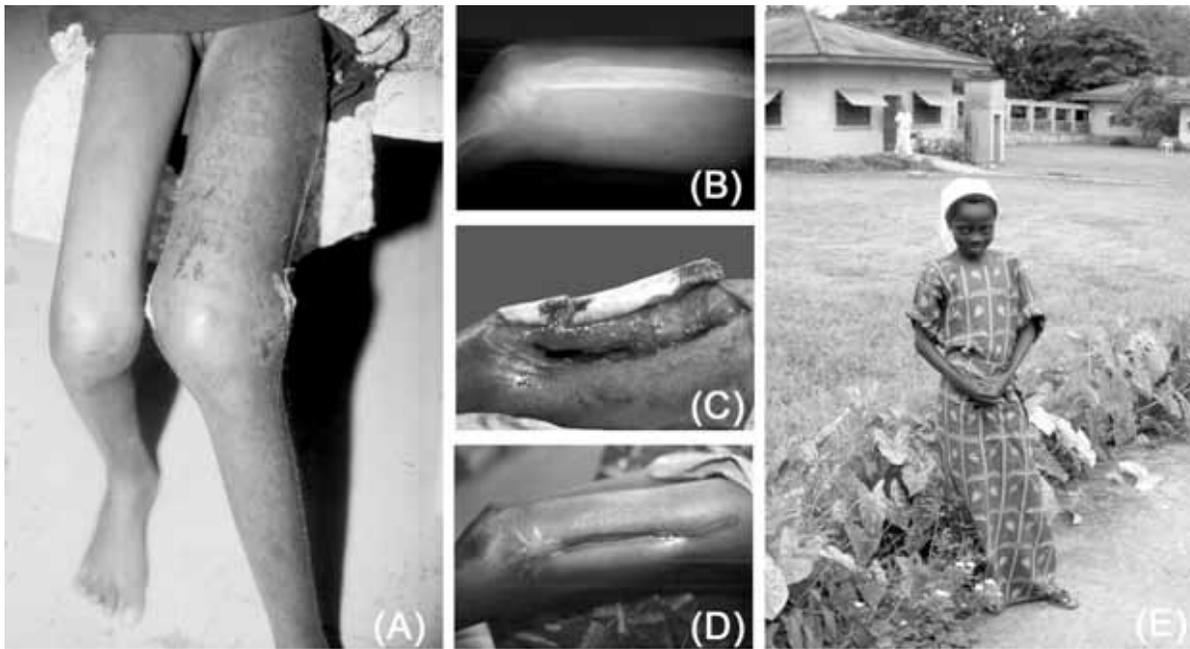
Stage 4 HO in a 12-year-old female with sickle-cell (SS) haemoglobin: (A) initial presentation with large abscess of left thigh, (B) x-ray showing giant sequestrum of femur, (C) drainage of abscess and sequestrectomy performed through a lateral thigh incision, (D) thigh wound, (E) child after complete healing by secondary intention with antibiotics used only to control the systemic sepsis.
